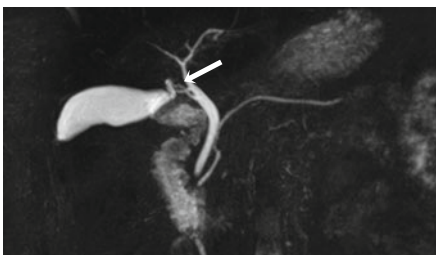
A 73-year-old female subject with history of cholecystectomy; no symptoms at the time of whole-body screening MRI. (a) Fat-saturated T2w TSE image reveals dilation of common bile duct and of cystic duct stump (*asterisk*) after cholecystectomy. (b) MRCP image shows no evidence of intraductal concretions in the common bile duct (*arrow*)
